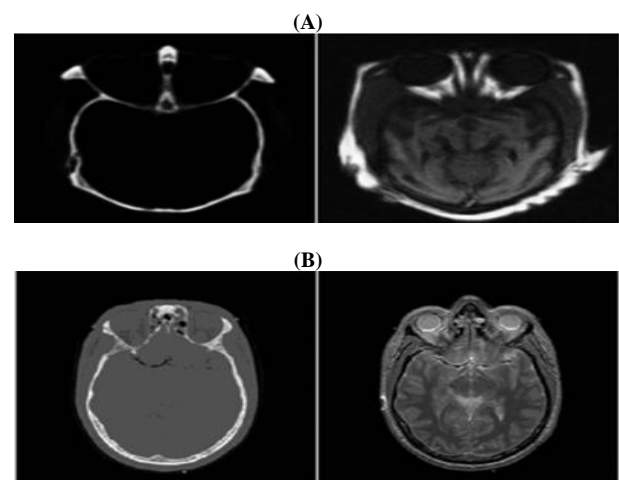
CT and MR Images A) Dataset 1 B) Dataset 2.
